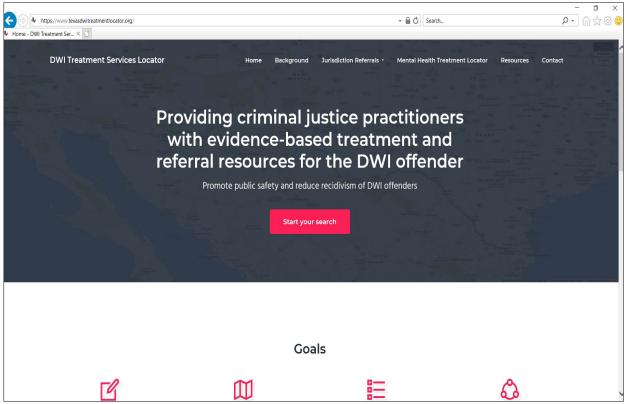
DWI Treatment Services Locator Homepage.
